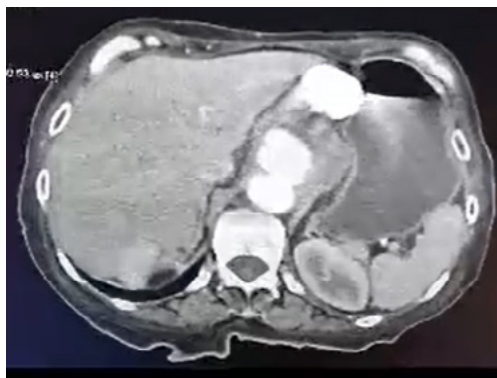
CTA showed Celiac artery aneurysm
